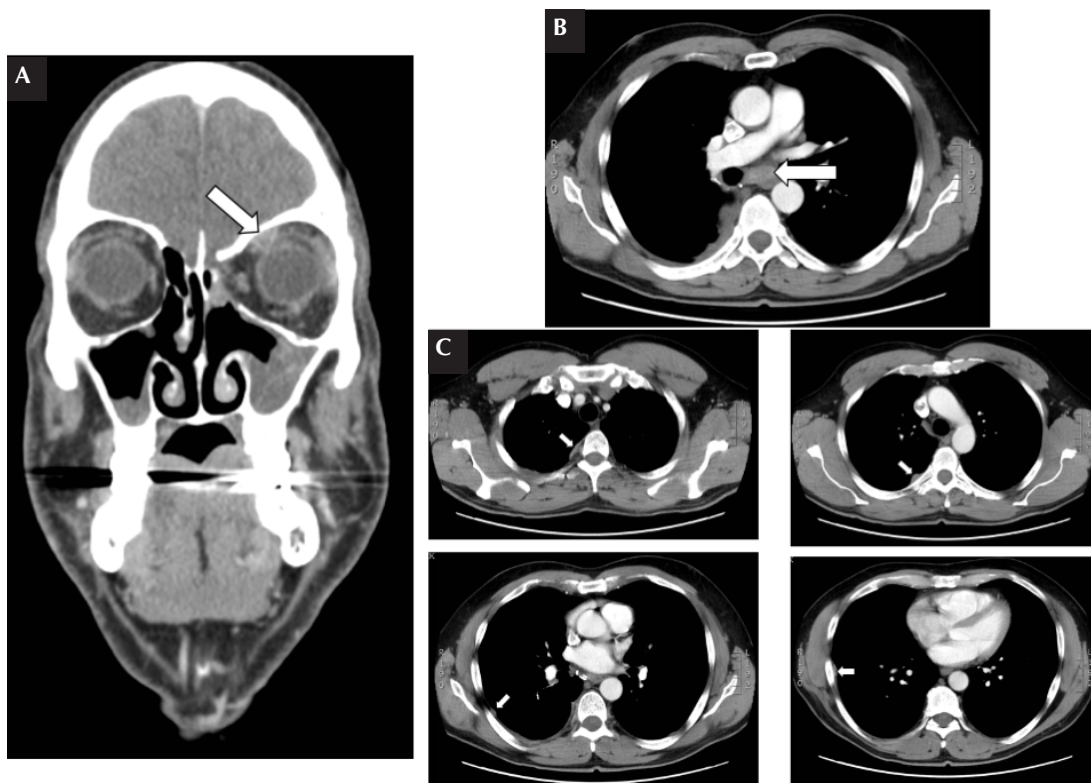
Computed tomography images demonstrating oligometastatic progression. (A) Coronal image of a new intraorbital lesion measuring 0.9x1.0x0.7 cm, adjacent to the anterior aspect of the superior oblique muscles (arrow). (B) Axial image of a new enlarged subcarinal node, measuring 1.2x2.8 cm (arrow). (C) Four axial images demonstrating pleural plaques (arrows).
